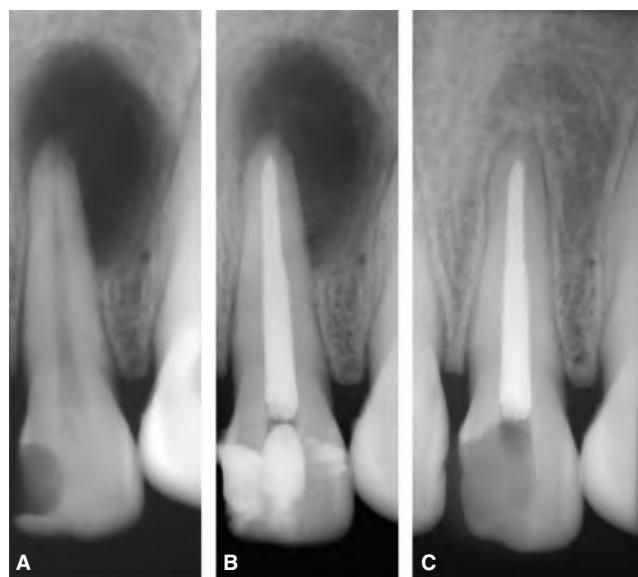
Healing of large periapical lesion in a maxillary lateral incisor of a 43-year-old female. A. Preoperative radiograph showing a large periapical radiolucency. Pulp vitality tests were negative. B. Immediate postoperative radiograph. C. Four-year follow-up radiograph showing resolution of the periapical radiolucency.
